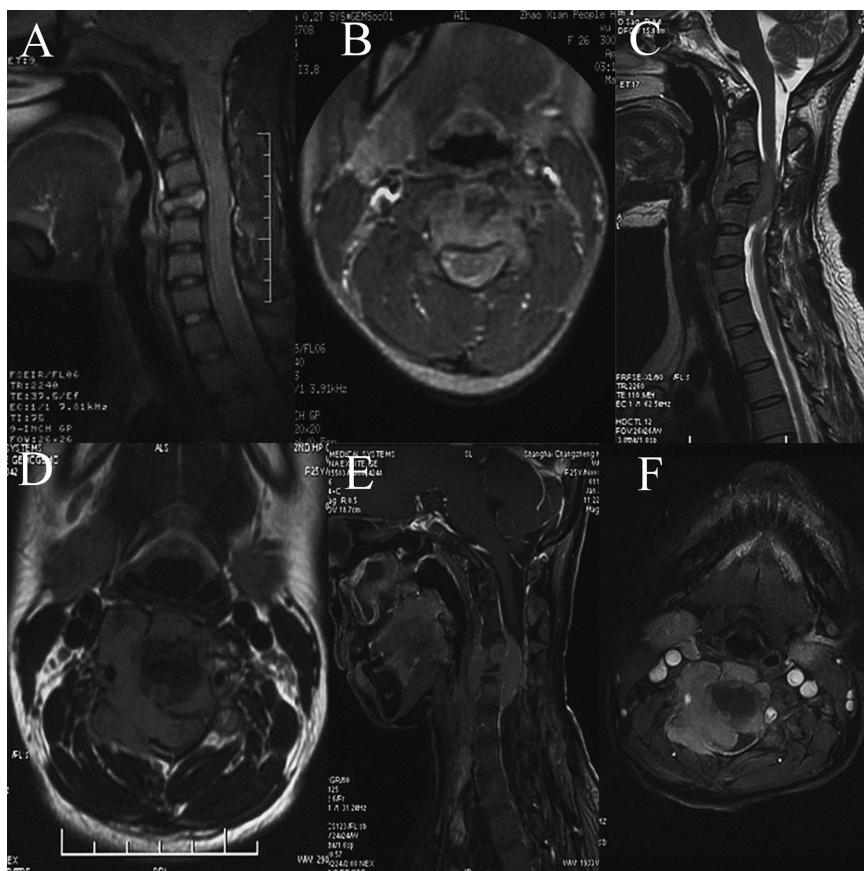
The process of tumor growth after pregnancy (no. 20): MRI of the sagittal (A) and axial (B) plane before pregnancy showing a vertebral compression fracture of C4. MRI of the sagittal (C) and axial (D) plane of T2; contrast-enhanced MRI of the sagittal (E) and axial (F) plane during pregnancy revealing a vertebral compression fracture of C4 and the compression of the cervical spinal cord by a large mass located on the right side of segments C3–C5 in the epidural regions. MRI indicates magnetic resonance imaging.
